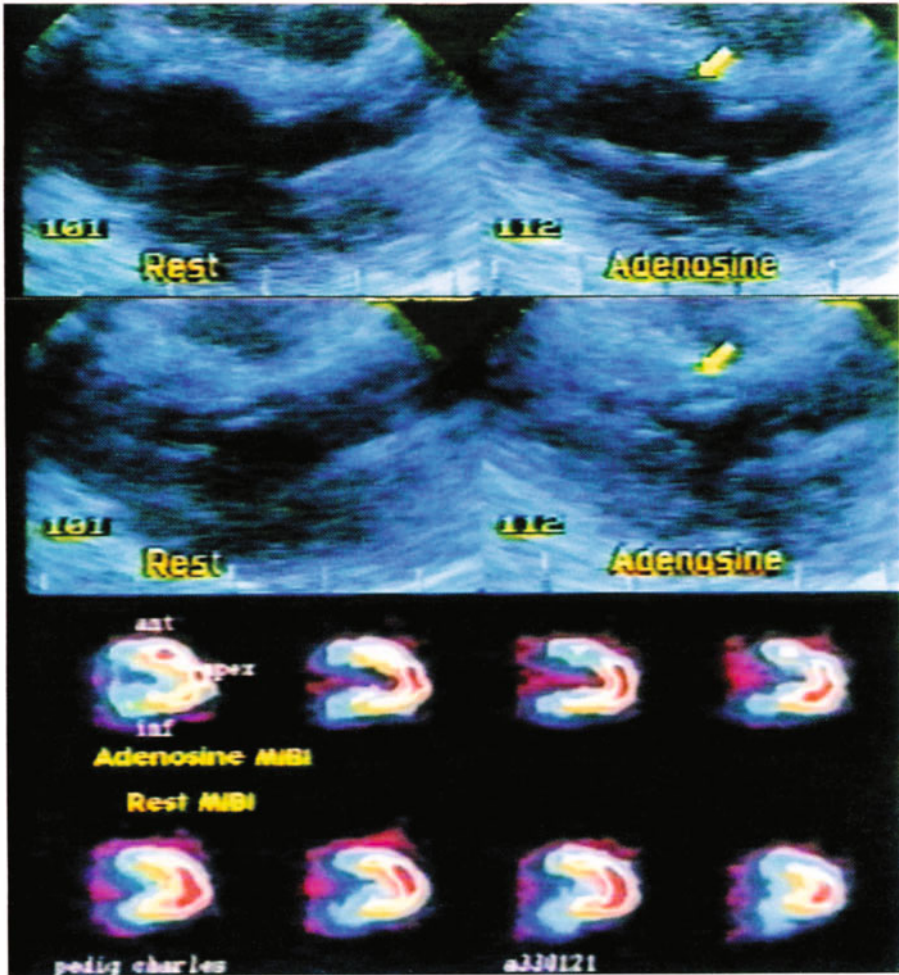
Adenosine stress echocardiography and MIBI-SPECT in a patient with normal coronary arteries and left ventricular hypertrophy. The hypertrophied septum (arrows) thickens normally between diastole (top) and systole, at rest and during dipyridamole stress. Scintigraphy reveals a false positive perfusion defect after adenosine, with a partial defect at rest.
